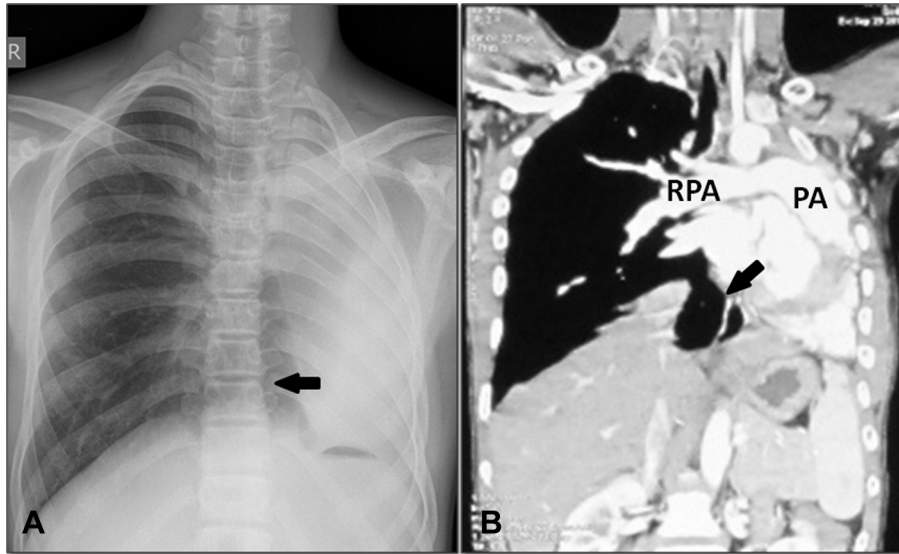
A. Radiograph of the chest showing opacified left hemithorax with crowding of ribs, ipsilateral tracheal and mediastinal shift. B. CECT chest coronal view demonstrating absent left lung parenchyma and dilated main (PA) and right pulmonary artery (RPA). Herniation of the right lung is indicated (Solid black arrow).
